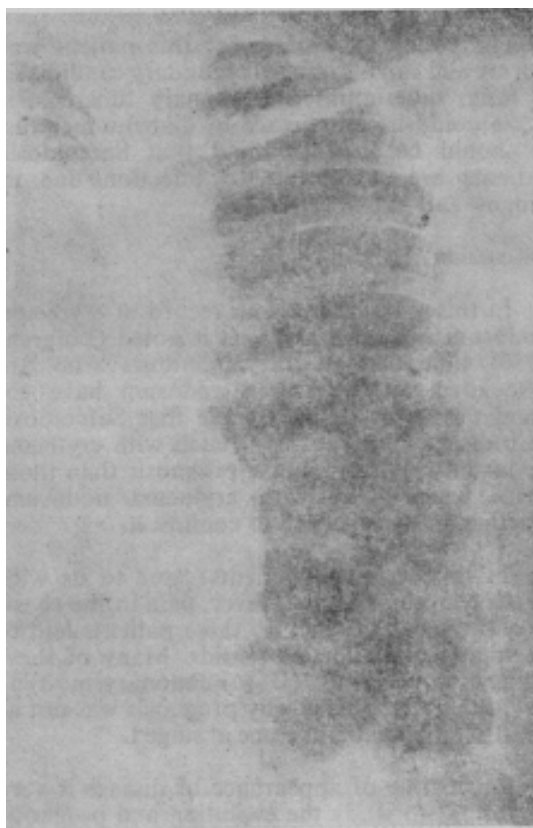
X-ray of the chest of the patient shows BHL + pulmonary mottling (specially on left upper zone).
